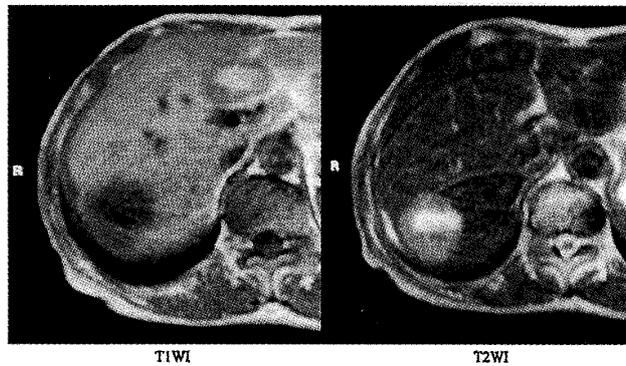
Abdominal MRI: Abdominal MRI showed a tumor that was low signal intensity on the T1-weighted sequence and high signal intensity on the T2-weighted sequence. MRI showed a fluid-fluid level in the tumor, suggesting the presence of an intratumoral hemorrhage.
